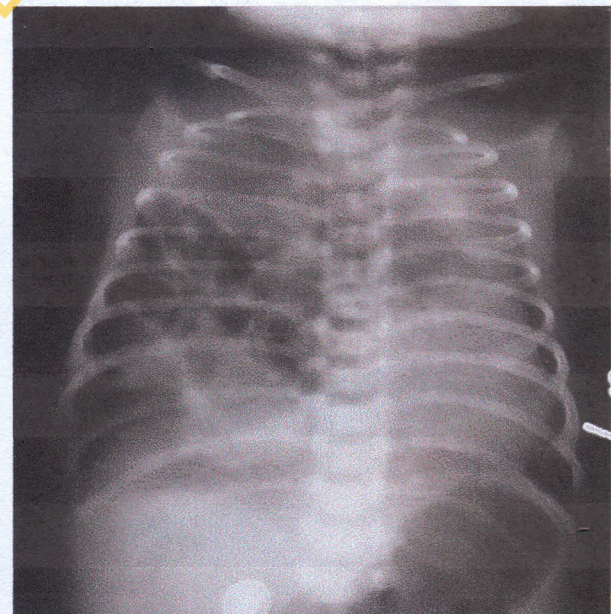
A 3-day-old boy with congenital cystic adenomatoid malformation of right lung. Chest radiograph shows air-filled cysts that mimic intrathoracic bowel herniation
